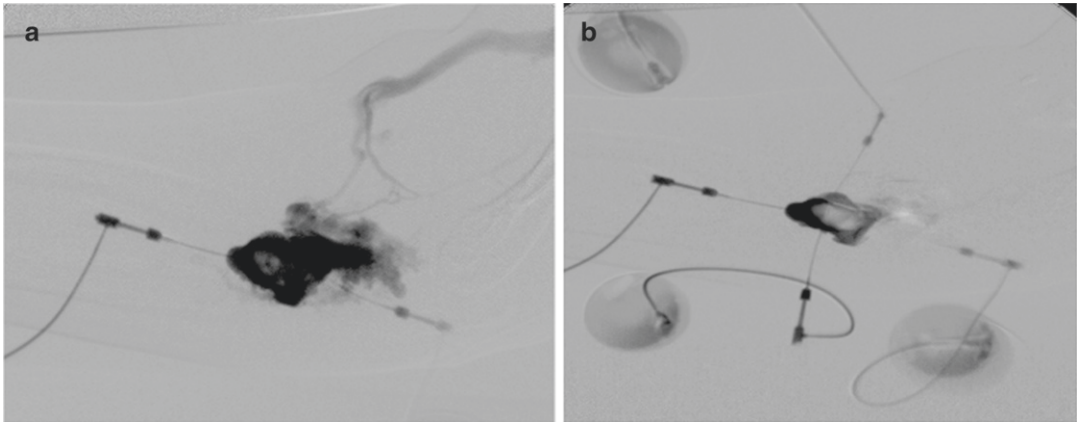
Venous malformation (VM) sclerotherapy. Intramuscular thigh VM. Ultrasound (US) guides successful puncture of the venous channels using 20 gauge sheathed needles (a). After backflow of blood is obtained
